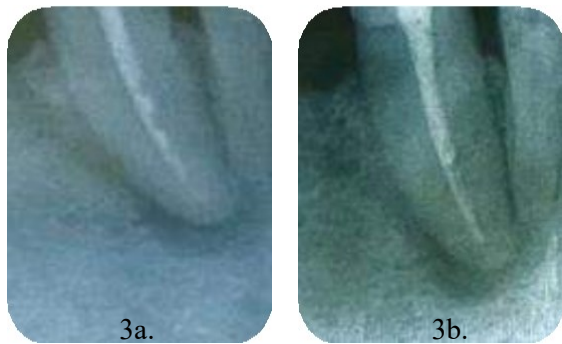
Post-obturation periapical radiograph of tooth 43. Figure 3b. Post-obturation radiograph at 3 weeks showing no changes to the apical radiolucency.
